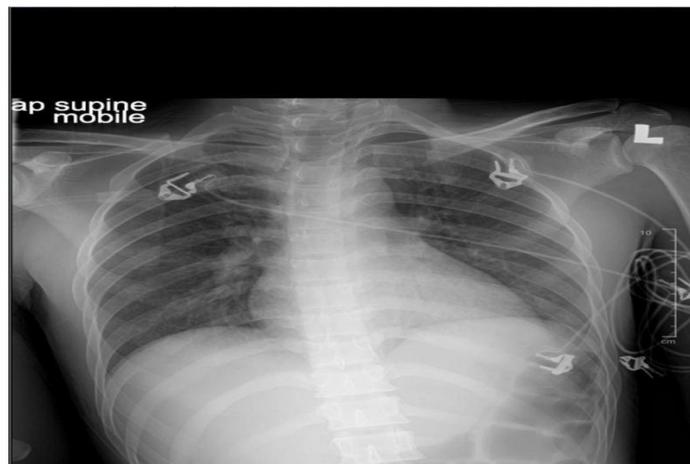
Chest X-Ray during treatment on 22nd Jan 2019 (Last day of ECMO)
